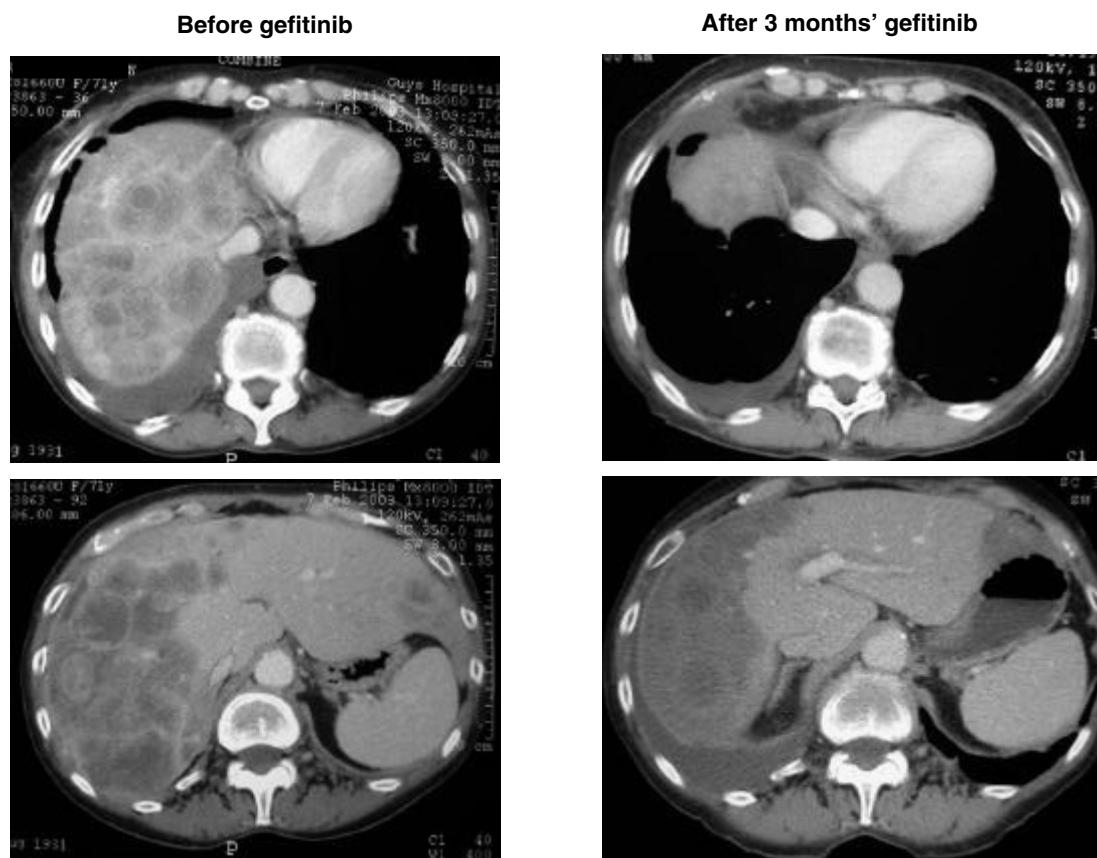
CT chest and abdomen scans of a patient with NSCLC and liver metastases, before and after treatment with gefitinib. Reproduced with permission from Dr Peter Harper.
